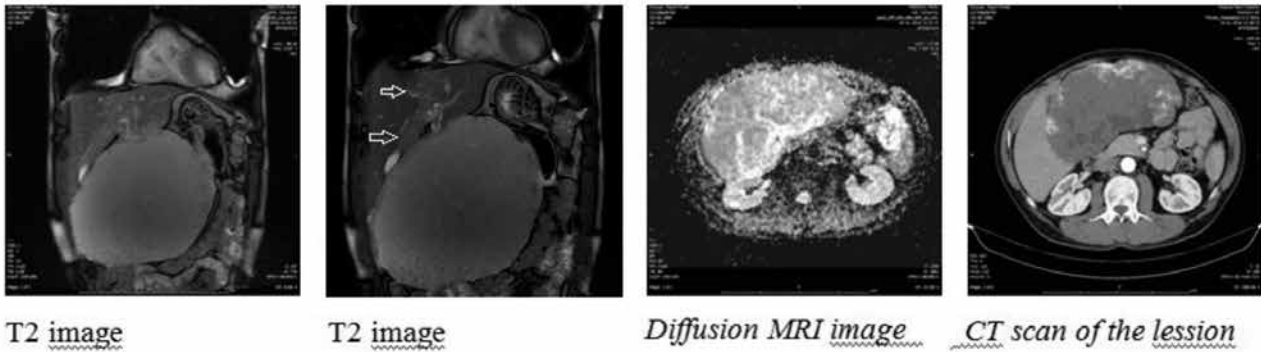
Abdomen MRI and Thorax CT images
